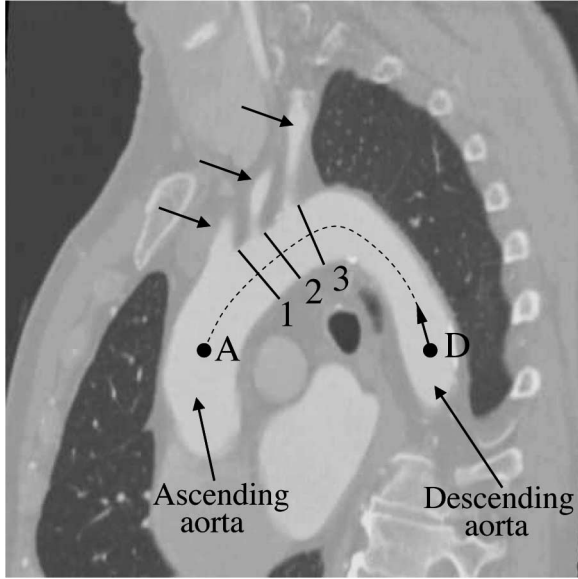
2-D section of a 3-D CTA dataset showing the aortic arch with sketched centerline, marked points A and D, and points 1, 2, and 3 distal to the supra aortic branches.
